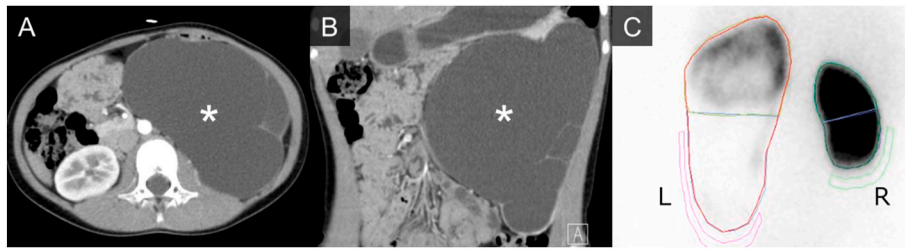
Preoperative imaging examination findings. (A), (B) Contrast-enhanced computed tomography showing hydronephrosis of the lower moiety (asterisk). The renal pelvis is severely dilated, compressing the renal parenchyma of the lower moiety. (A) Transverse plane. (B) Coronal plane. (C) The dimercaptosuccinic acid scan indicates that the differential renal functions of the left kidney and left lower moiety are 31.1 % and 1.7 %, respectively.
